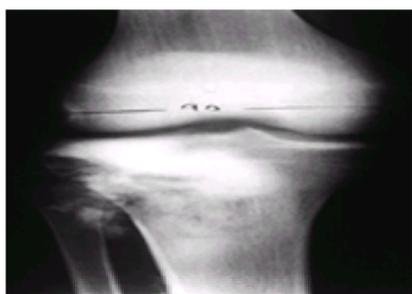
This is an anteroposterior plain radiograph of an 18-year-old man with an osteosarcoma of his proximal tibia. There is increased density in the proximal tibia associated with cortical destruction and extraosseous bone formation. Biopsy was confirmatory.
